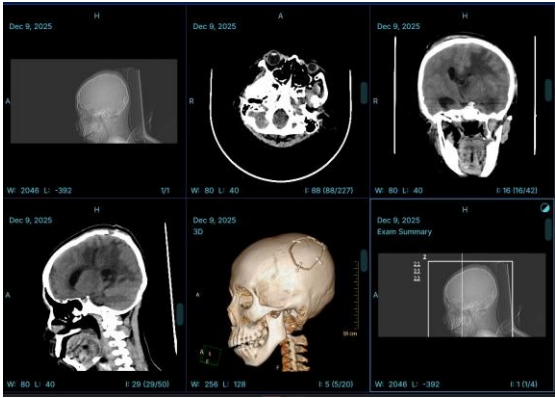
CT scan of the head dated December 9, 2025
